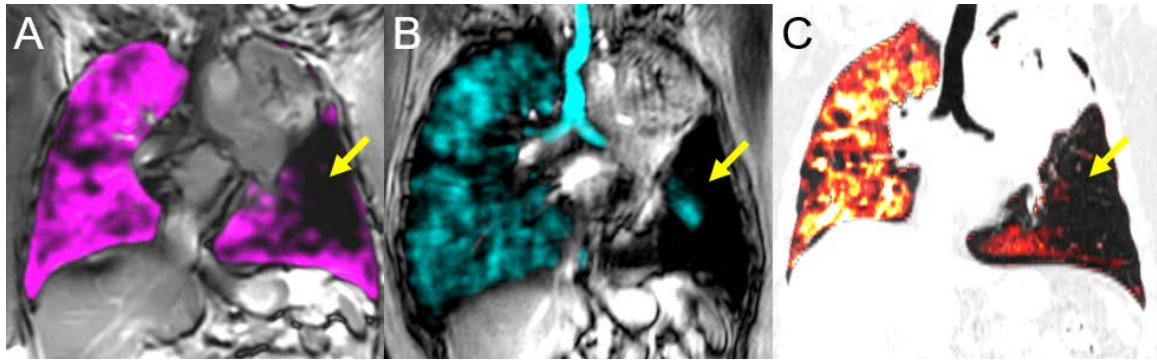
MRI and 4DCT ventilations images of a representative patient with stage III non-small-cell lung cancer
